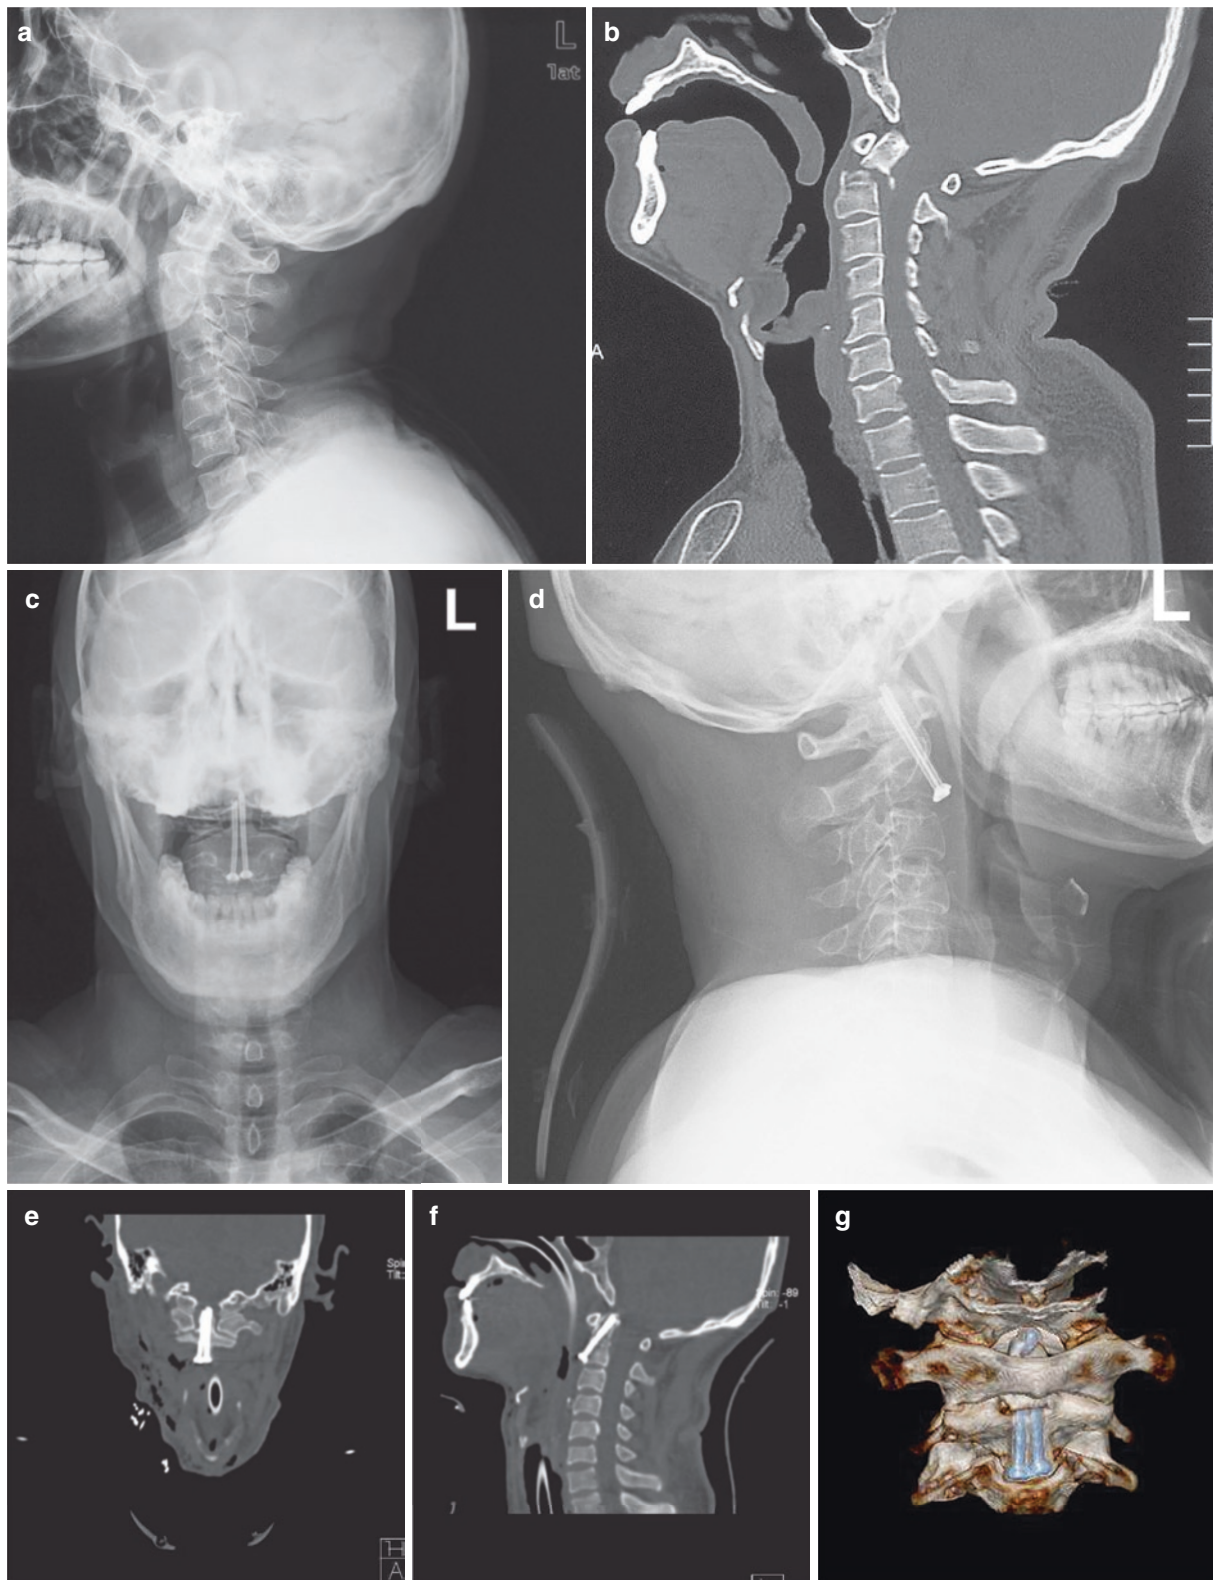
Internal fixation with a cannulated screw for an odontoid process fracture (a) A preoperative lateral radiograph: The odontoid process was fractured, and the atlas was dislocated posteriorly. (b) Preoperative sagittally reconstructed CT plain scans: There was a transverse fracture at the base of the odontoid process, which belonged to an Anderson type II fracture. (c, d) Radiographs at the open-mouth and lateral positions after anterior screw fixation of the odontoid process fracture. (e) Postoperative reconstructed CT plain scan at the coronal
